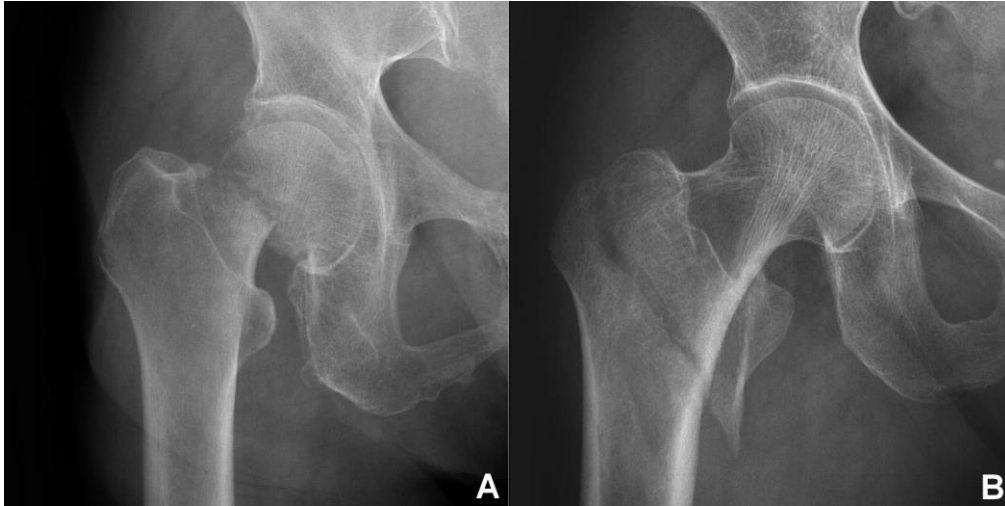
Radiographs showing typical hip fractures, femoral neck fracture(A) and femoral intertrochanteric fracture(B)
